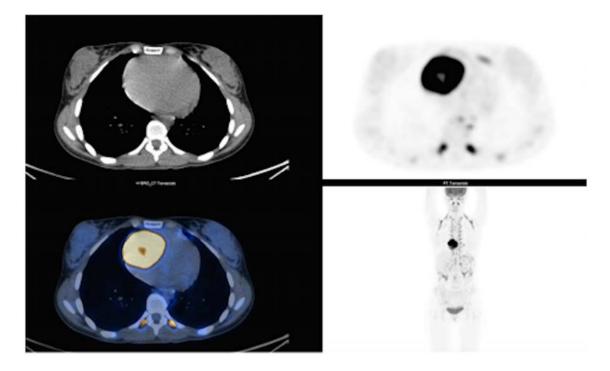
¹⁸F-FDG PET/CT showing the mass to be intensely hypermetabolic with central necrosis.
